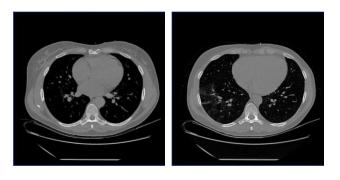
The two type of pictures we want to test with our model. These CT scans are one of our teamates' mother's. We chose this two image because they are quite different from each other so we can predict more real diagnostics.
